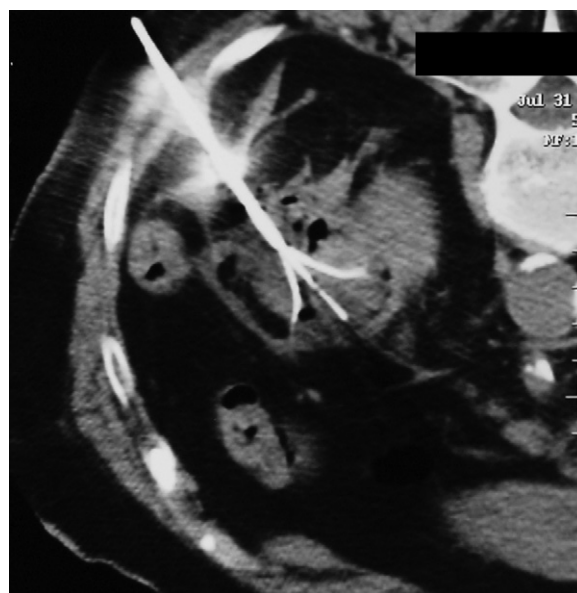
Computed tomography with tines deployed.
